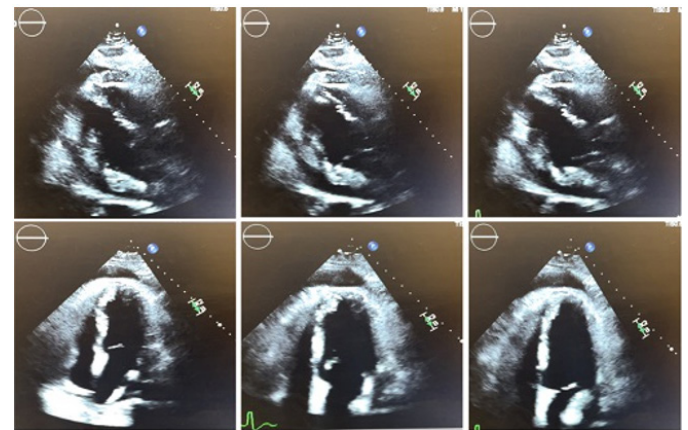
Repeat echocardiogram showing hemodynamically significant pericardial effusion with diastolic collapse. Top images: Parasternal long; Bottom images: Apical 4-chamber.
